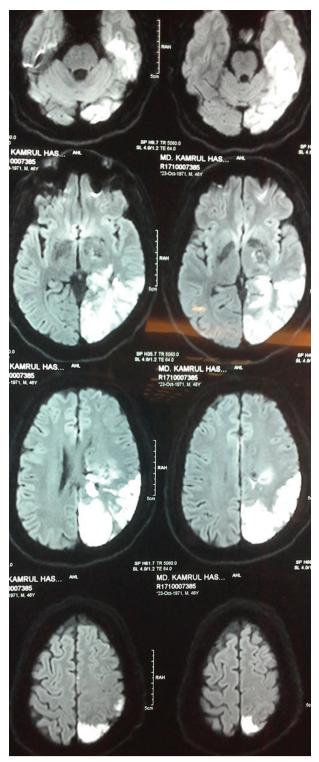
MRI of brain showing acute infarction in left parieto-occipito-temporal region.*
